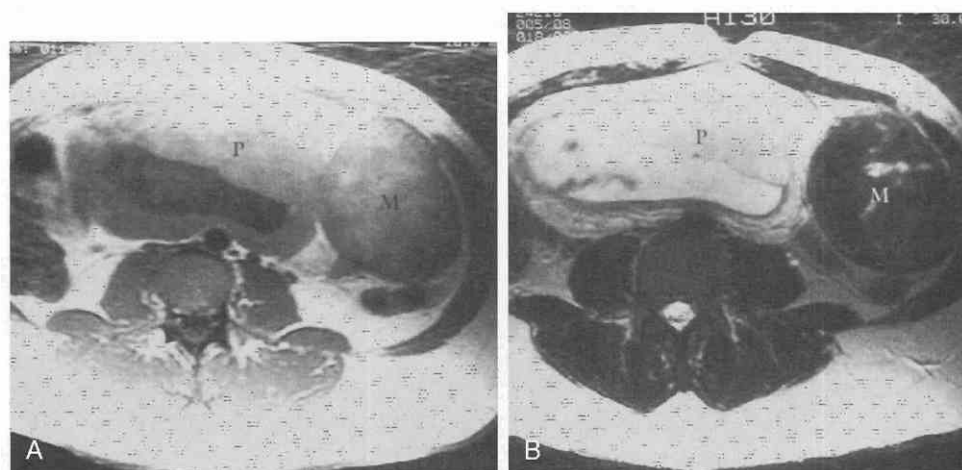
Adnexal mass in a pregnant patient. A previous ultrasound examination had shown a large, complex, partially solid mass. *A*, Axial spin-echo image (TR = 700 msec, TE = 12 msec) shows the placenta (P) and a mass in the left adnexa (M). *B*, Axial T2-weighted, fast spin-echo image (TR = 3800 msec, TE_{eff} = 126 msec) demonstrates the gravid uterus with the anterior placenta (P) as well as the left adnexal mass (M). The low signal intensity of the mass is consistent with a pedunculated leiomyoma. Small areas of hemorrhagic infarction are evident within the mass. TE_{eff}, effective echo time.
